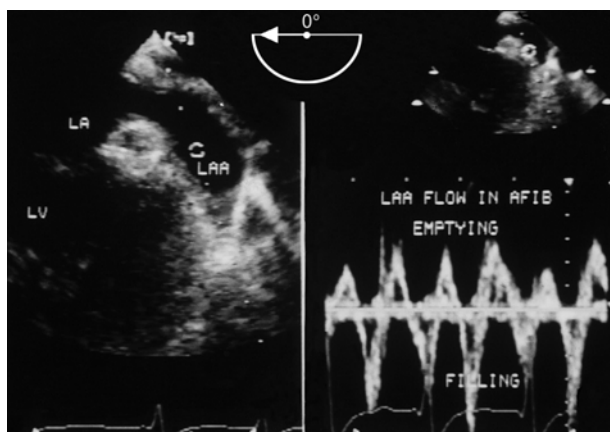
(Left). Left atrial appendage, with pulsed Doppler sample volume. (Right). Recording of emptying (upward) and filling (downward) velocities in atrial fibrillation.
